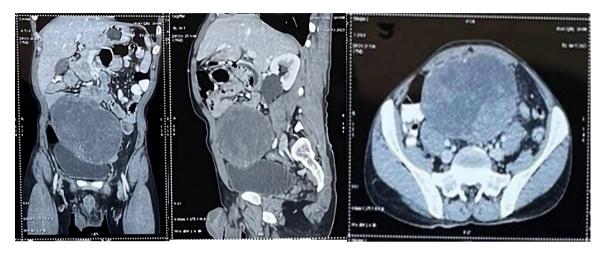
Computed tomography imaging as seen above, in coronal, sagittal and transverse planes respectively
